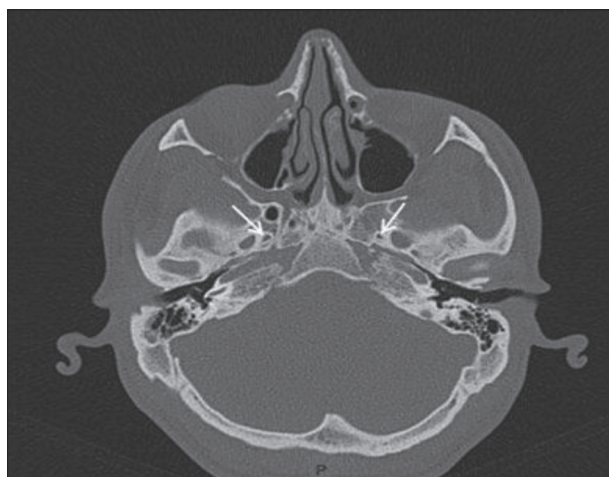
Bilateral foramen (white arrow) on a computed tomography scan
